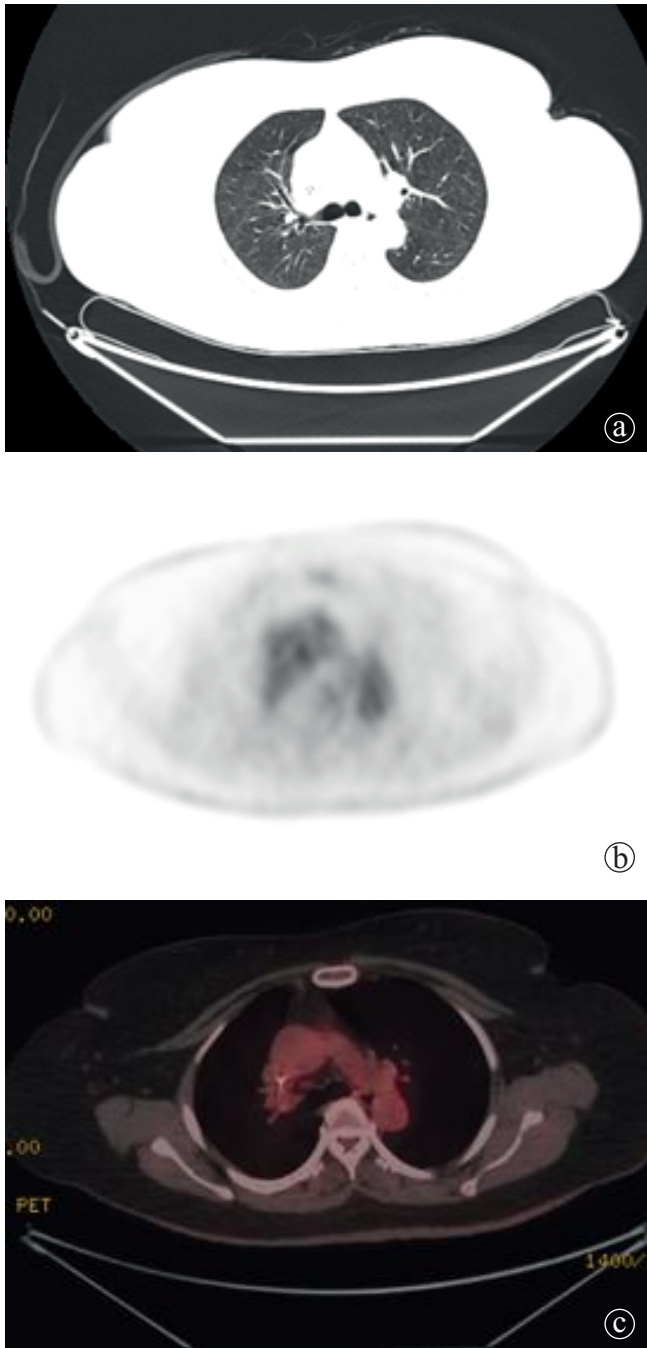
a) CT, b) PET and c) fusion PET/CT axial slices of the follow-up scan showing disappearance of the previously noted hypermetabolic activity in upper lobe of the left lung.
